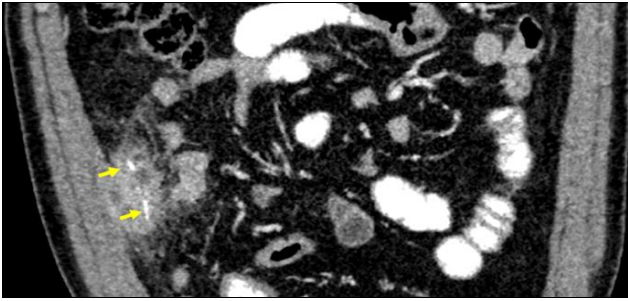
Contrasted CT abdomen with selected coronal reformatted view at lumbar level. Right lumbar thick-walled collection with two needle-like opacities within (yellow arrows) and surrounding fat streakiness
